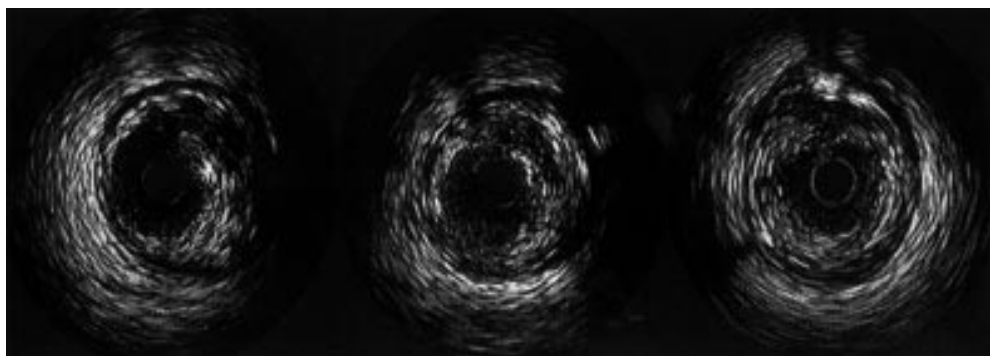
Intravascular ultrasound images (left and centre) showing a double lumen between 12 and 3 o'clock postintervention. The right image shows the same lesion at six month follow up with the unhealed false lumen seen between 11 and 2 o'clock.
